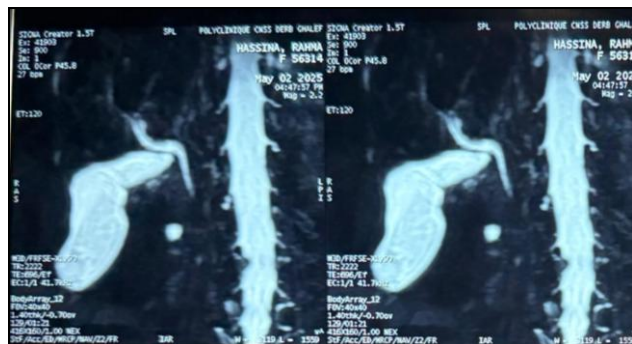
Abdominal MRI showing a lobulated enhancing lesion in the gallbladder fundus (arrow) with no hepatic invasion
